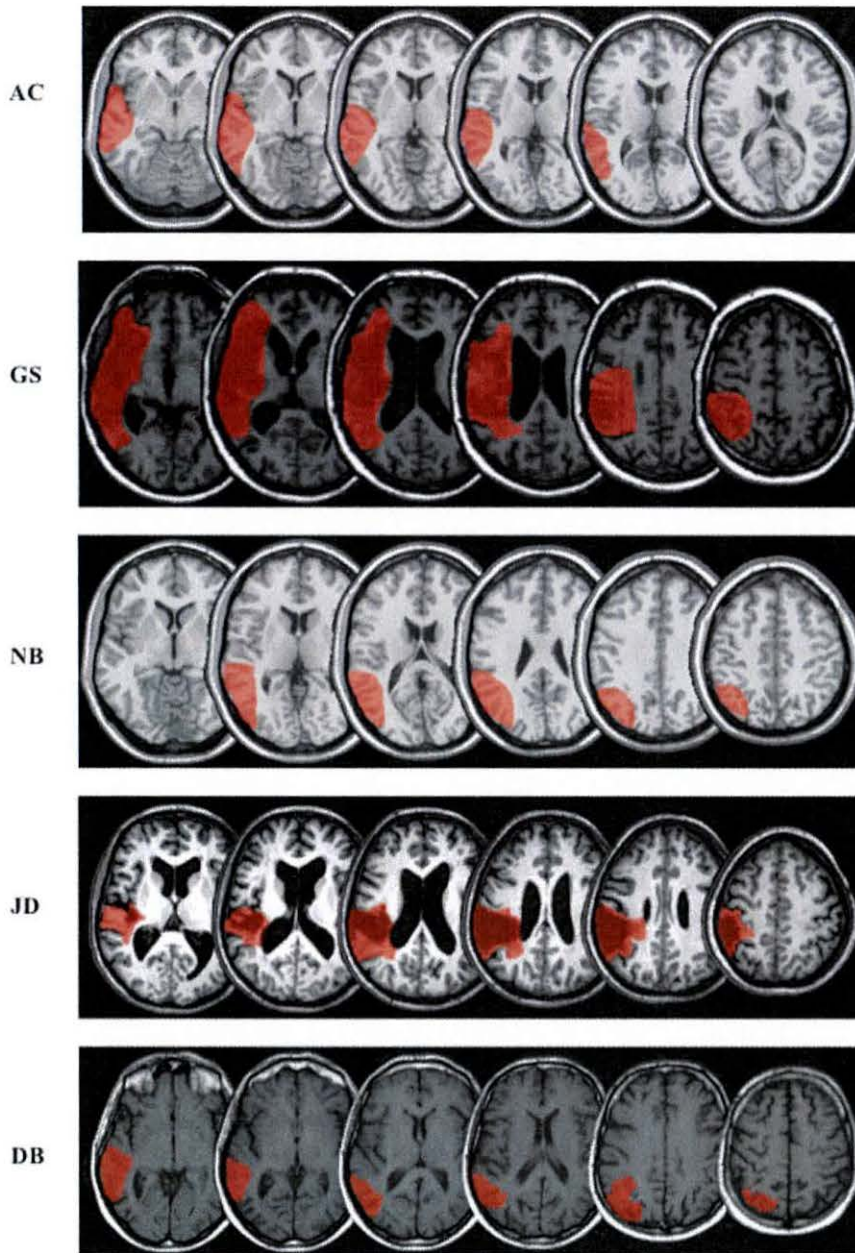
Axial MR slices showing lesions for the five patients. Images are presented in radiological format (the right side of the brain presented on the left side of the image) with affected areas in red. No MRI scans were available for patients AC or NB so lesions for these patients were drawn from CT scans onto a normal template brain. Note that AC's stroke progressed after the CT scan was taken, and his lesion is probably much more extensive than that shown in the reconstruction. For example, the figure shows preserved motor cortex and internal capsule, but the patient exhibited dense left-sided weakness and sensory loss.
